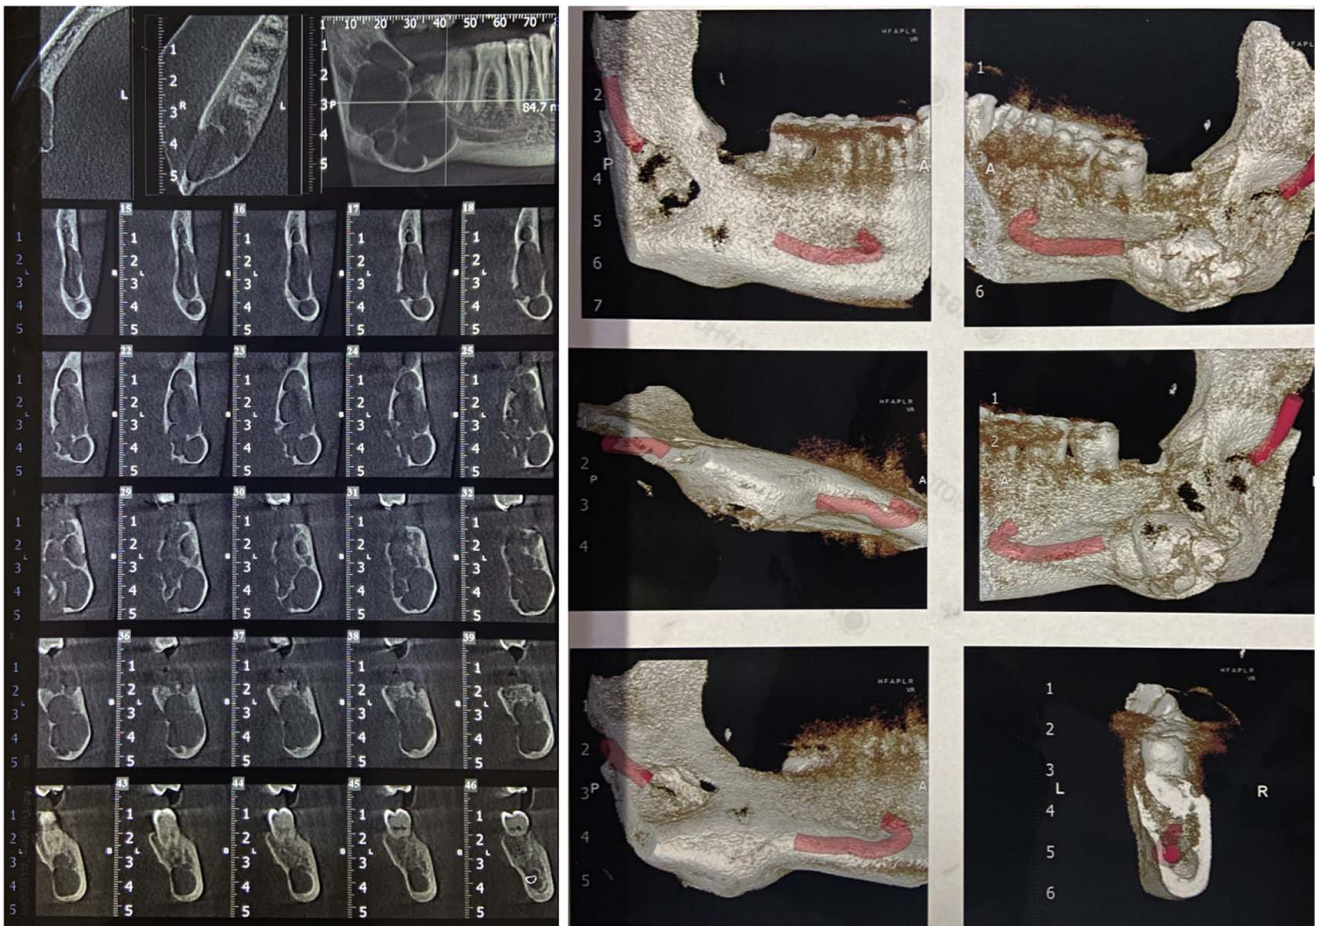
Cone beam computed tomography scan of the right mandibular angle shows the expansion of lingual cortex.
